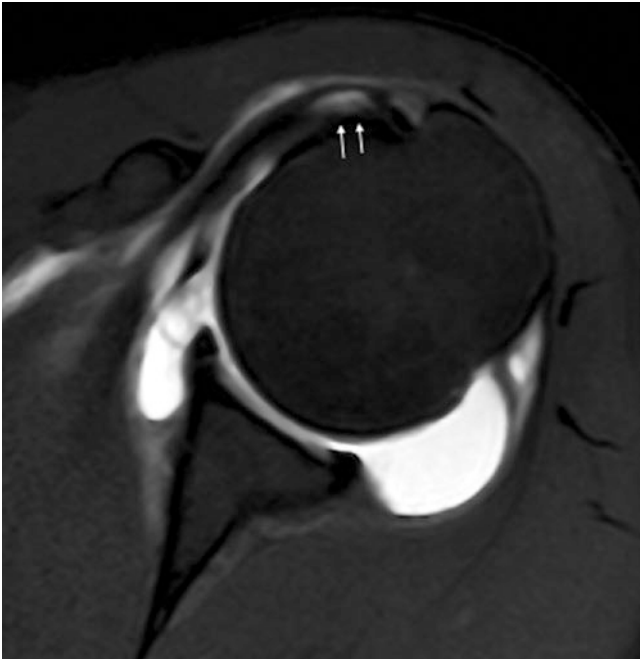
Axial arthro-MRI FSE T1 fat sat WI demonstrates partial articular side tear of the subscapularis
